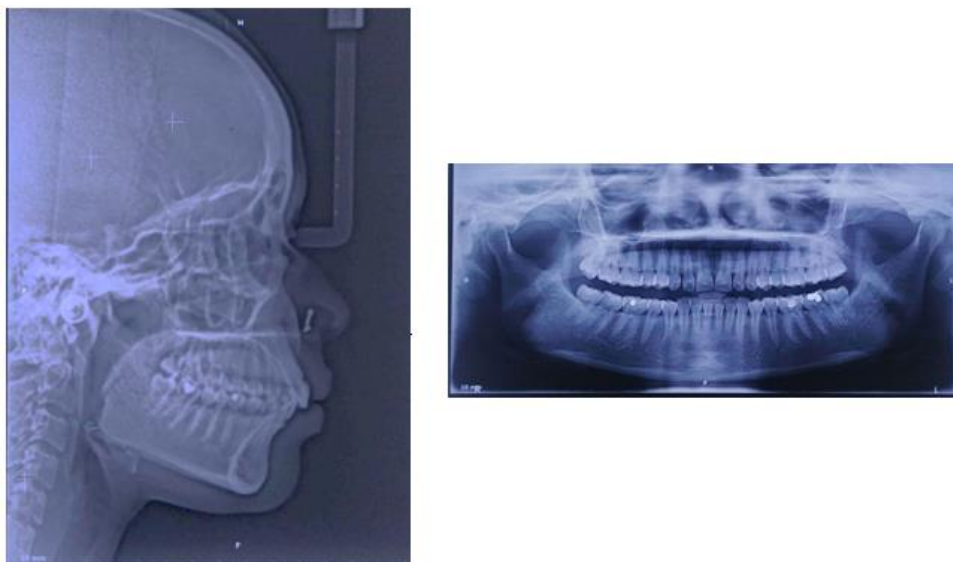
Pre Treatment Extra oral, Intra Oral Photos and Radiographs
